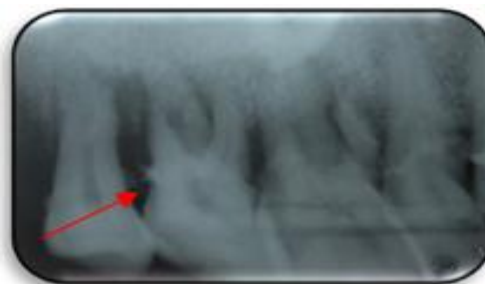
Intraoral periapical radiograph shows severe bone loss irt 15, 16, 17 with remnants of trabeculae in the interdental space between 17, 18.
